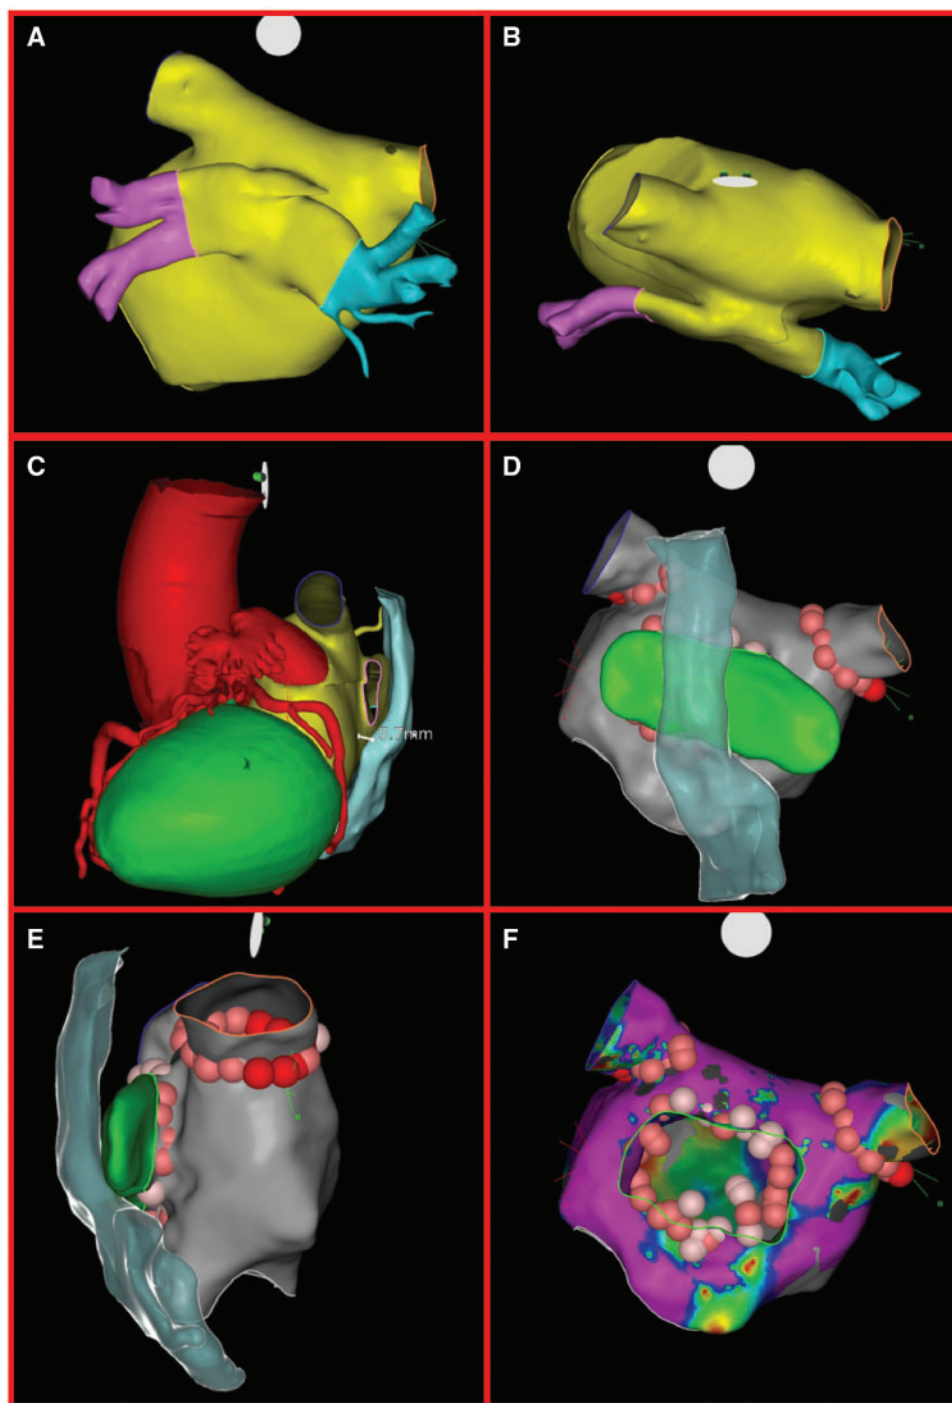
Postero-anterior (A) and cranial (B) computed tomography angiography reconstruction of the left atrium reconstruction highlighting the confluence of the inferior pulmonary veins in a common trunk, behind the left atrium's posterior wall. (C) Left lateral computed tomography angiography imaging cardiac reconstruction displaying the position of critical contiguous structures; particularly highlighting the distance between the oesophagus and the origin of the common posterior trunk at the posterior left atrium wall (5.7 mm). Postero-anterior (D) and right-lateral (E) left atrium fast anatomical mapping at Carto[®] 3 system (Biosense Webster Inc., USA) merged to computed tomography angiography reconstruction to demonstrate the position of the oesophagus; red and pink tags are the locations of the radiofrequency delivery. (F) A detail of ablation points in relation to the common posterior trunk ostium in the postero-anterior projection.
